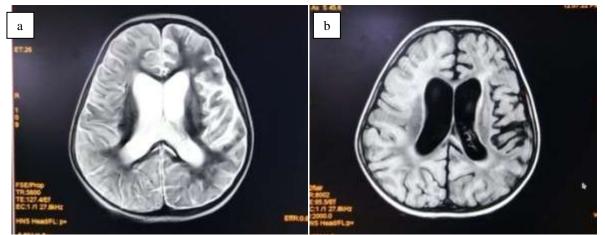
On axial scan of MRI brain, there is atrophy of the left fronto-parietal cortex with prominent sulci and gyri.
